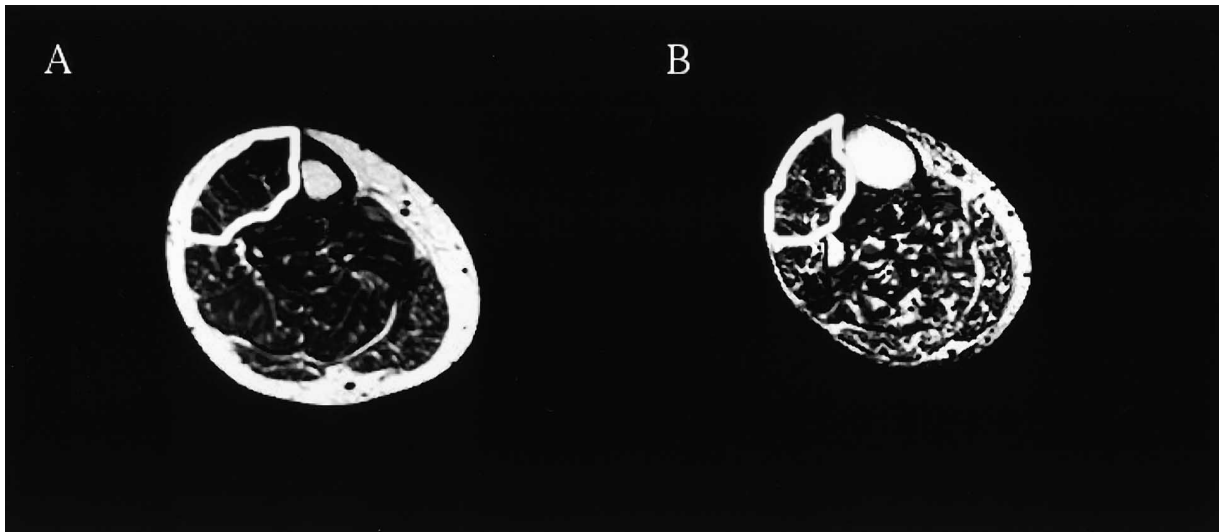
Representative magnetic resonance images of the lower right leg. (A) A 72-year-old female control subject. (B) A 70-year-old female hemodialysis subject. Contractile tissue appears dark, while fat and bone appear white. The region of interest (anterior compartment) is outlined in white. There is more noncontractile tissue in the anterior compartment of the dialysis subject.
